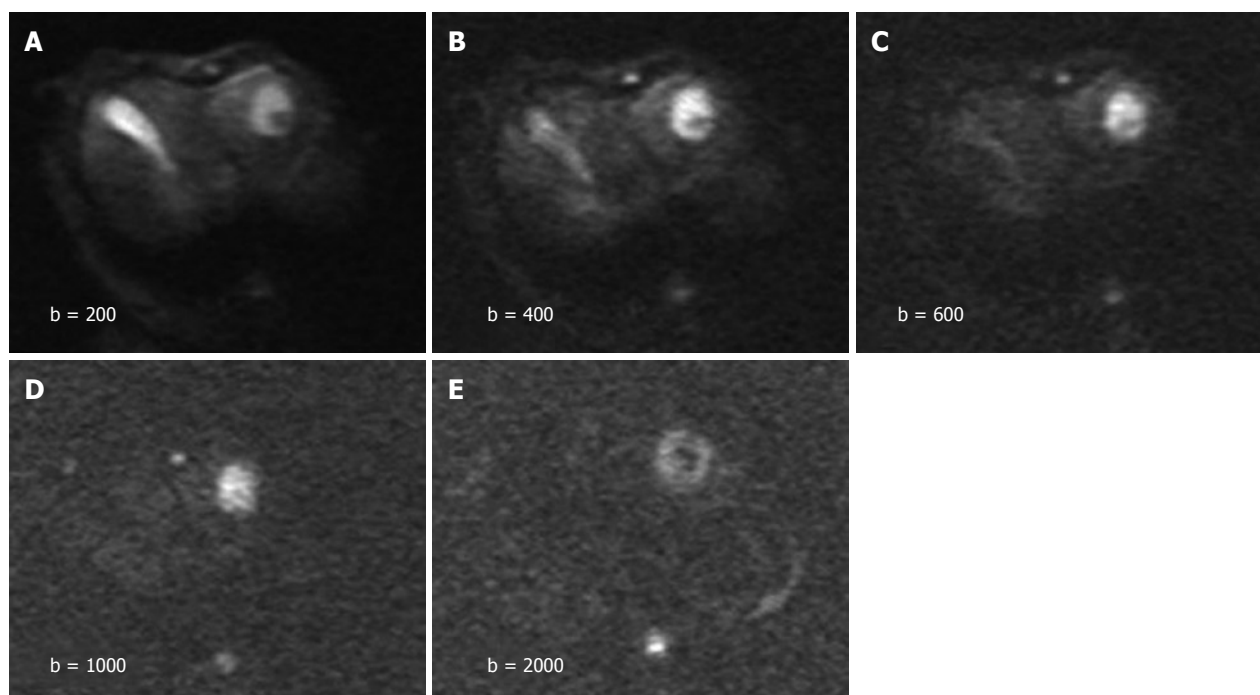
Diffusion-weighted images obtained with different b-values. A and B: High signal intensity in tumors and hyperintense gallbladder on b200 and b400 DWI; C-E: Hyperintense tumors and invisible gallbladder on b600, b1000 and b2000 DWI. The image qualities degrade with increasing b values.
